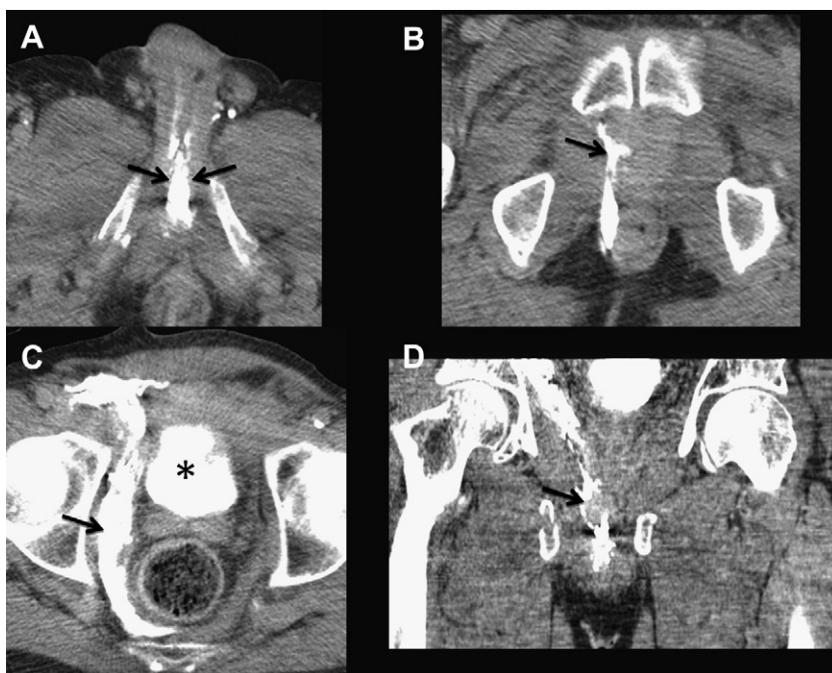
Type IV urethral injury. A CT retrograde urethrogram was performed (arrows). (A) Axial CT scan at the level of the penis demonstrates contrast opacification of the bulbar urethra. (B) More superiorly, there is contrast extravasation above the urogenital diaphragm (arrow). (C) More superiorly, at the level of the superiorly displaced urinary bladder, excreted contrast from prior CT (asterisk) is seen within the bladder. Extraperitoneal contrast is noted along the right pelvic sidewall (arrow). (D) Coronal CT scan demonstrates urethral injury extending into the bladder base with extravasation of contrast and clot (arrow). This was confirmed at cystoscopy.
